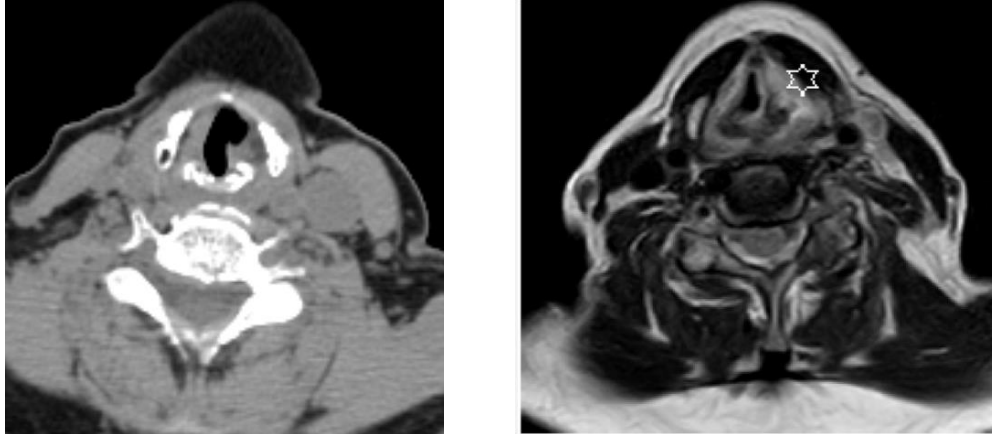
non contrast axial CT and axial M T2WIs images show mild antero-medial deviation of the left arytenoid cartilage
